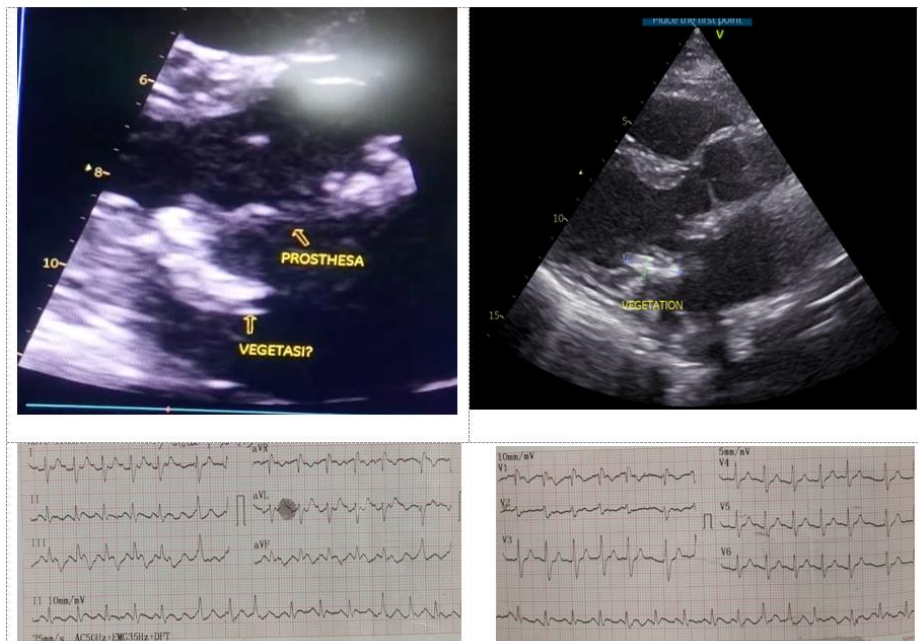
(above): Echocardiograph showing paravalvular vegetations at mitral valve
